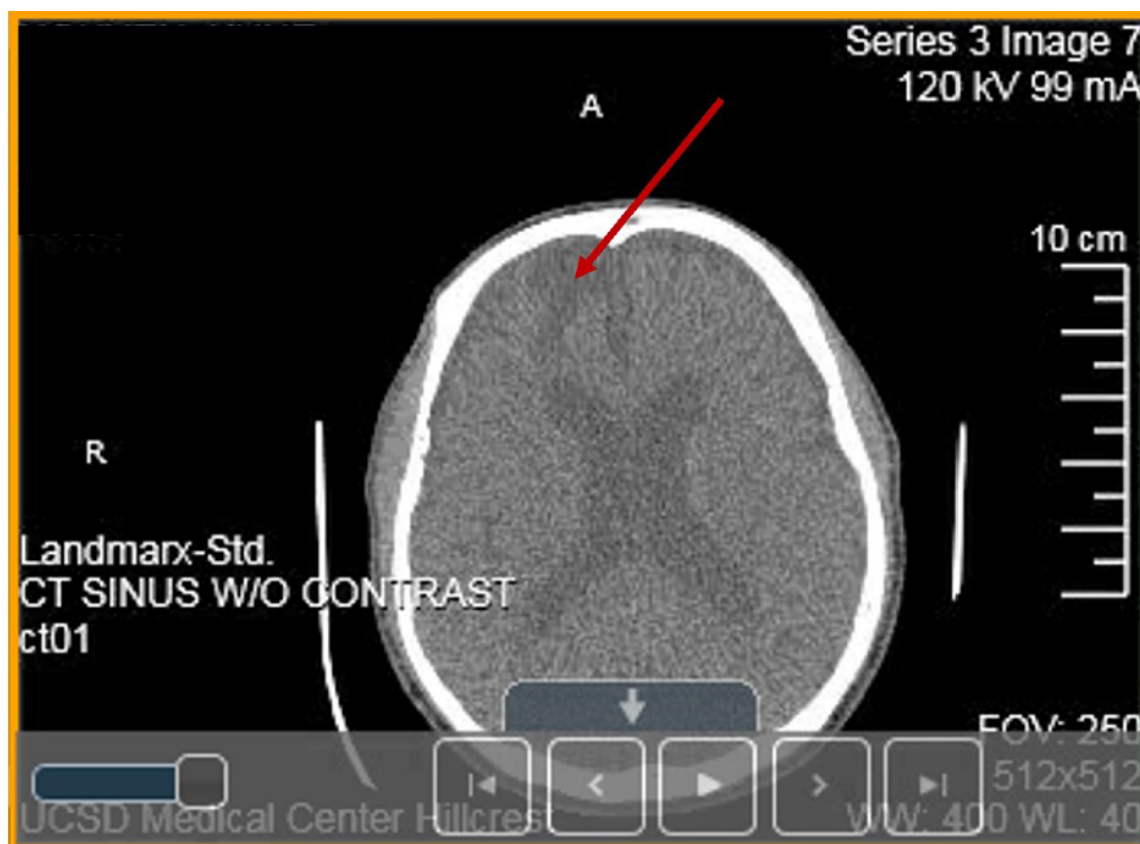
Non-contrast cerebral computed tomography scans of the paranasal sinuses, acquired with 0.625 mm axial slices, and reformatted in the coronal and sagittal planes. Limited portions of the brain are visualized, showing encephalomalacia/gliosis in the anterior right frontal lobe, suggestive of sequelae from prior trauma (dark area at the top-left corner, red arrow). Image adopted from a study published by Nguyen.²⁵
